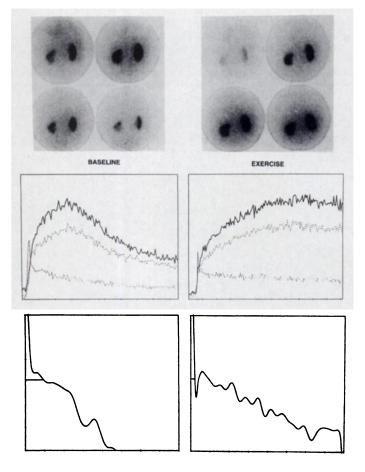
Rest scintigram in Subject 10, (top left panel, after administration of 1 mCi ¹²³I-OIH) shows slight renal asymmetry but otherwise normal appearance through 12 min. Deconvolved renogram for left kidney in lower left panel is normal. Right panel: 1 mCi OIH given during exercise shows progressive parenchymal accumulation for 12 min on scintigram and renogram. Deconvolved left renogram (lower right panel) shows prolongation of transit compared to the rest study (left).
